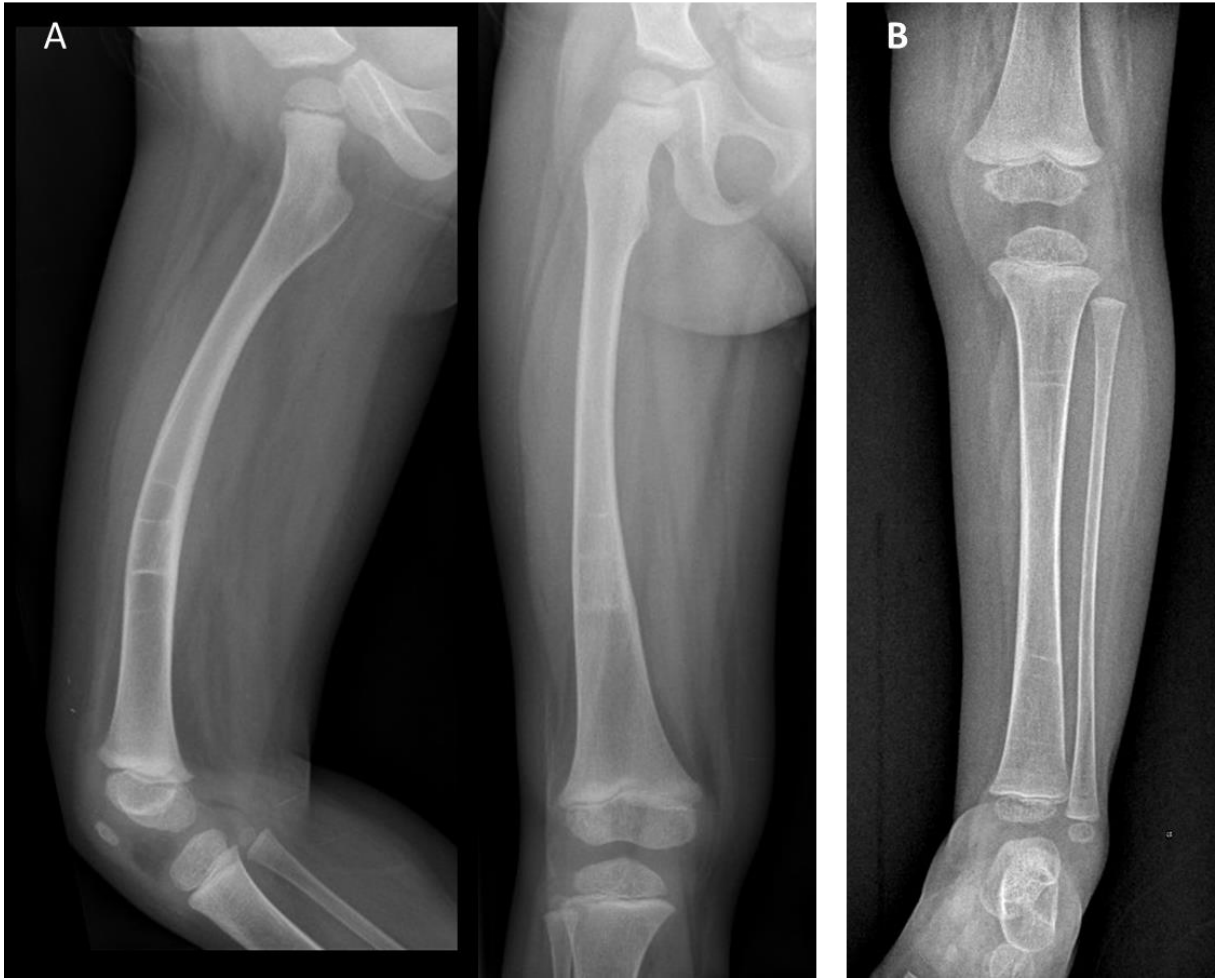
X-ray of Patient C.II.1 femur (A) and tibia (B) showing bone demineralization (2 years old)
